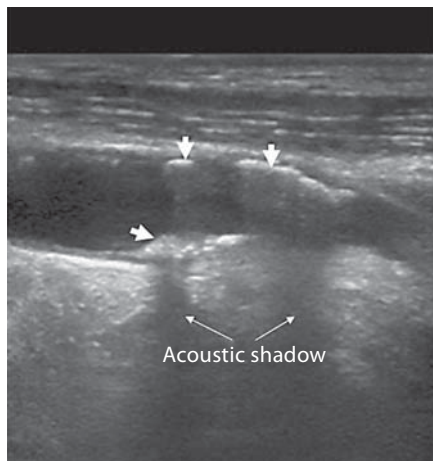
Ultrasound of calcified carotid plaques with an acoustic shadow.
